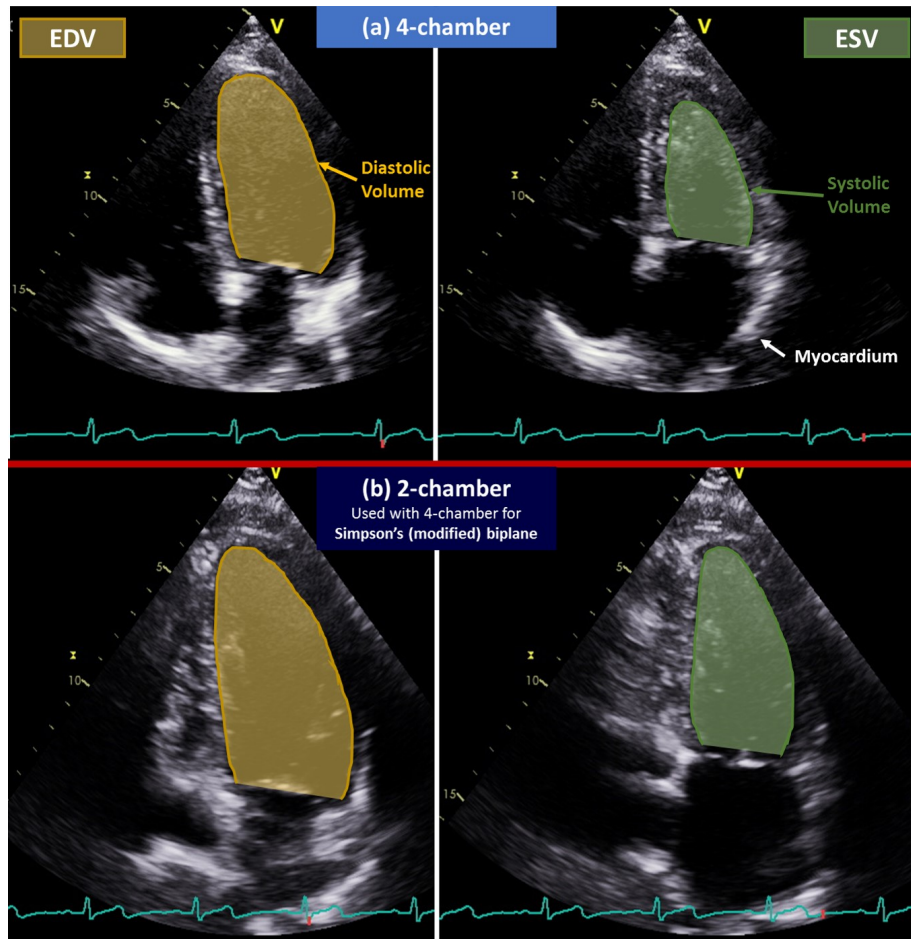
Echocardiographic single plane B-mode images of apical (a) 4-chamber and (b) 2-chamber views used primarily in the measurement of left ventricular volumes. Both views are used to calculate cardiac output via the Simpson's Biplane method. Stroke volume is estimated by measuring the area-change between end diastolic (EDV) and end systolic volumes (ESV) of the left ventricle, shown on the figure by yellow and green areas, respectively.
